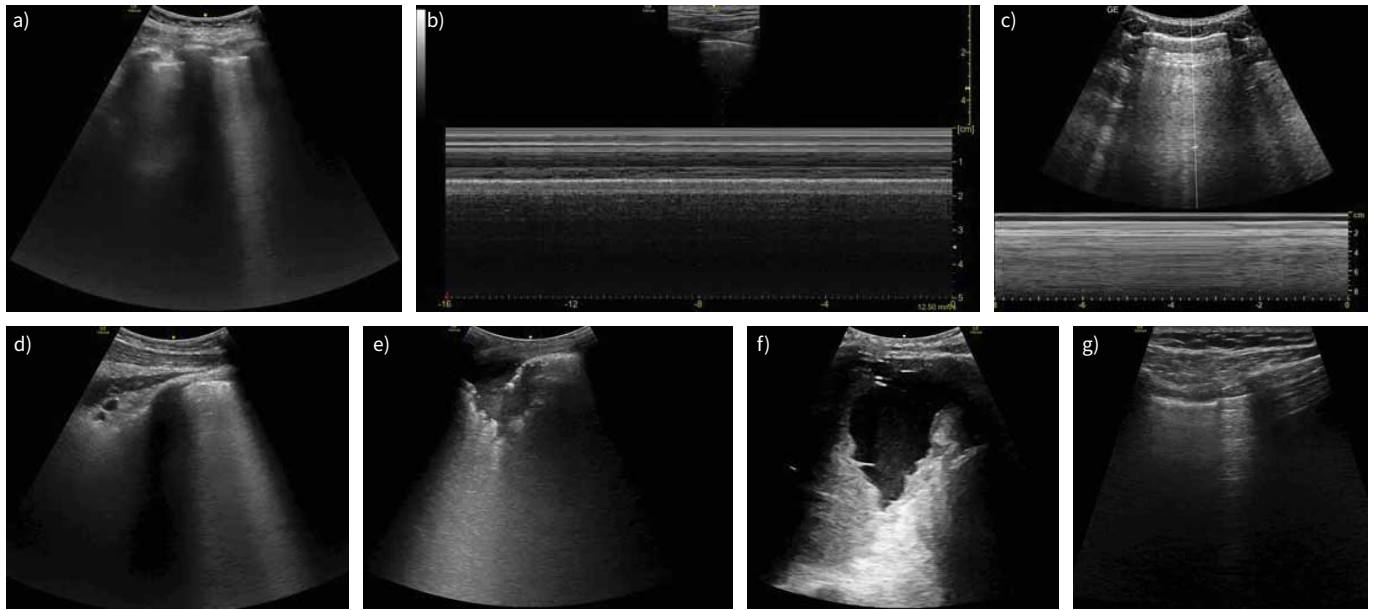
Typical signs on lung ultrasound. a) Bat sign. b) Seashore sign. c) Barcode/stratosphere sign. d) B-line. e) Consolidation. f) Pleural effusion. g) Lung point in pneumothorax.
